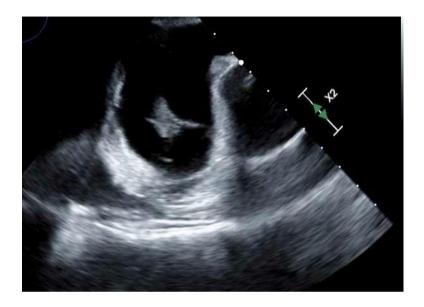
Transesophageal echocardiogram revealed mobile vegetation attached to the Tricuspid valve
